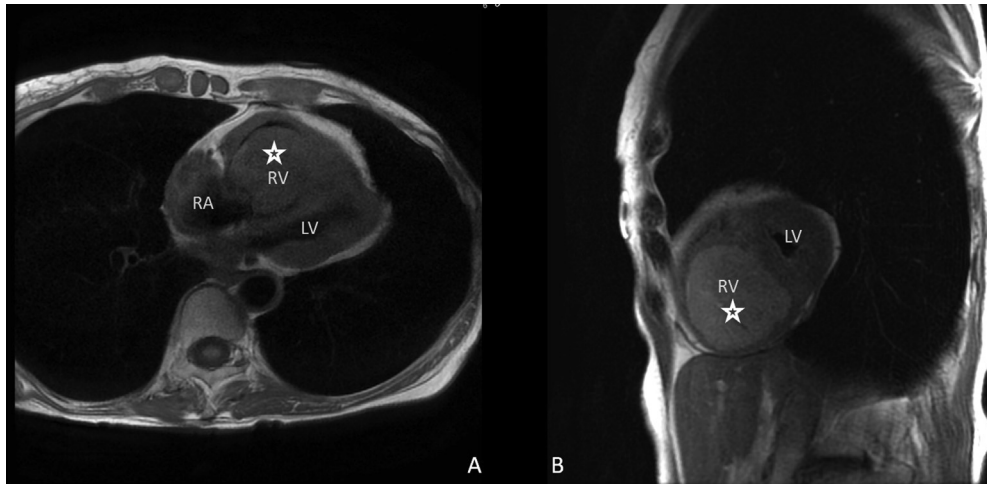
Cardiac MRI. (A) T1-weighted image showing isointense mass in the right ventricle and attachment site most likely near the right ventricular apex. (B) T2-weighted image, short axis, of the ventricles showing a hyperintense mass almost entirely filling the right ventricular chamber. The *star* indicates the mass. LV, Left ventricle; RA, right atrium; RV, right ventricle.
